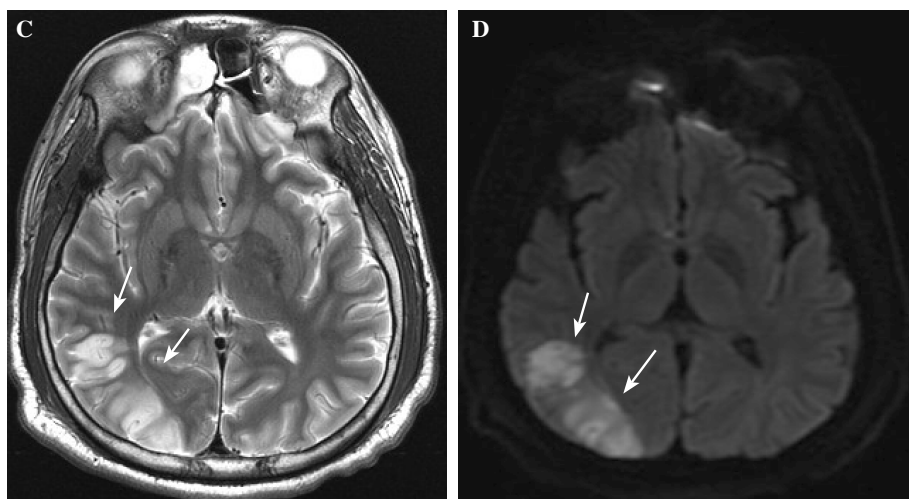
(C) Axial T2-weighted MRI shows hyperintensity over the right occipital lobe. (D) Axial diffusion weighted image of the same patient shows restricted diffusion in the right occipital lobe, consistent with an acute infarction.
